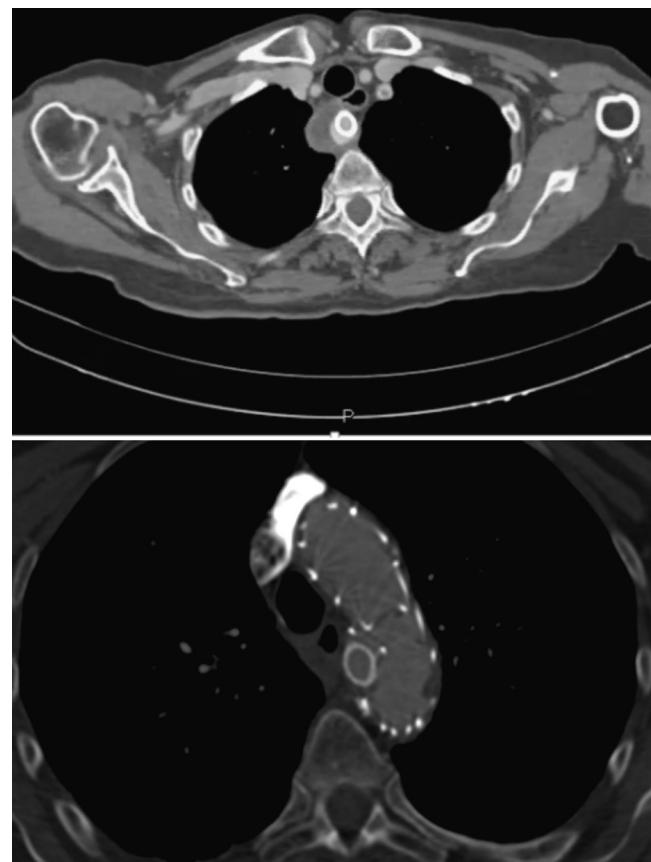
Angio-CT scan before discharge with a slow endoleak due to the "gutters".
